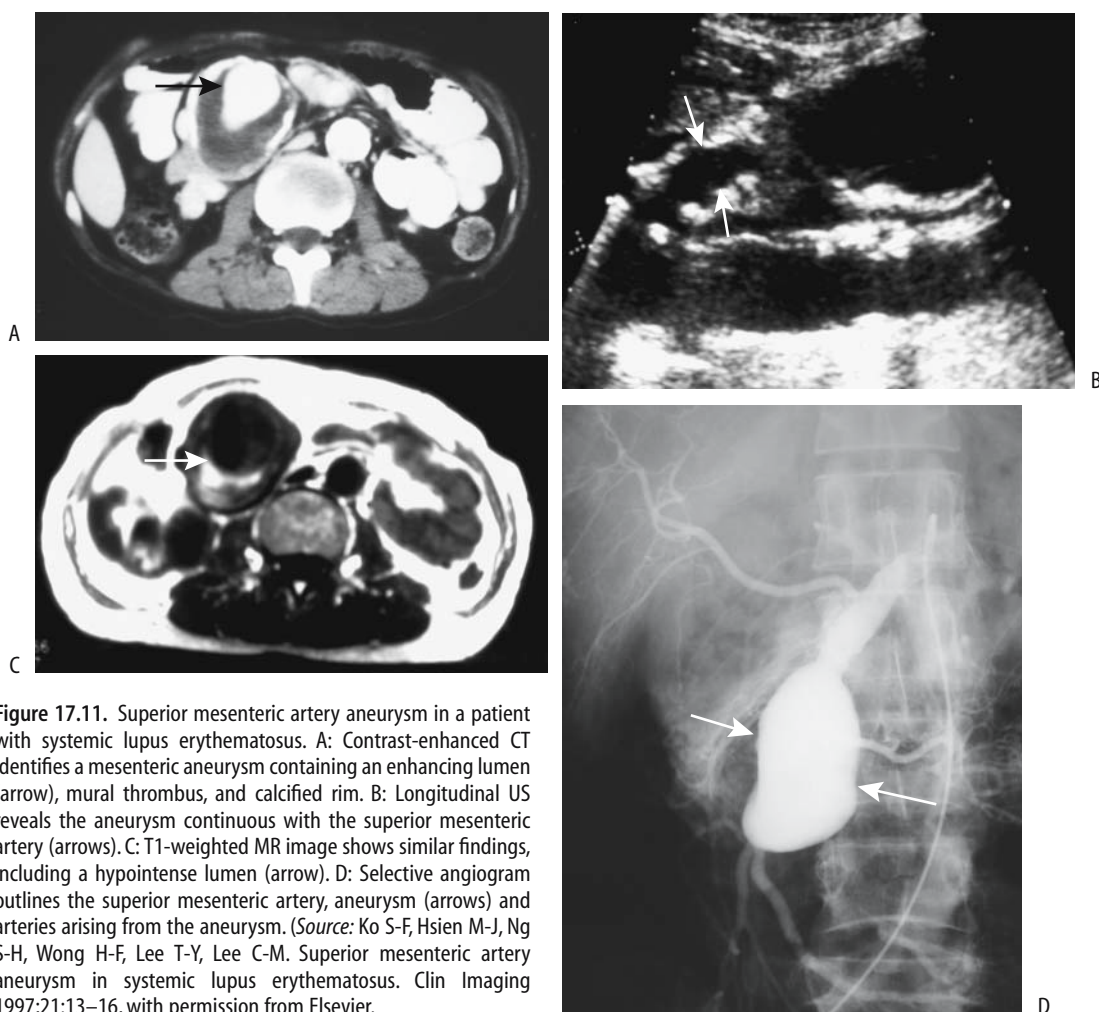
Superior mesenteric artery aneurysm in a patient with systemic lupus erythematosus. A: Contrast-enhanced CT identifies a mesenteric aneurysm containing an enhancing lumen (arrow), mural thrombus, and calcified rim. B: Longitudinal US reveals the aneurysm continuous with the superior mesenteric artery (arrows). C: T1-weighted MR image shows similar findings, including a hypointense lumen (arrow). D: Selective angiogram outlines the superior mesenteric artery, aneurysm (arrows) and arteries arising from the aneurysm. (Source: Ko S-F, Hsien M-J, Ng S-H, Wong H-F, Lee T-Y, Lee C-M. Superior mesenteric artery aneurysm in systemic lupus erythematosus. *Clin Imaging* 1997;21:13–16, with permission from Elsevier.)
